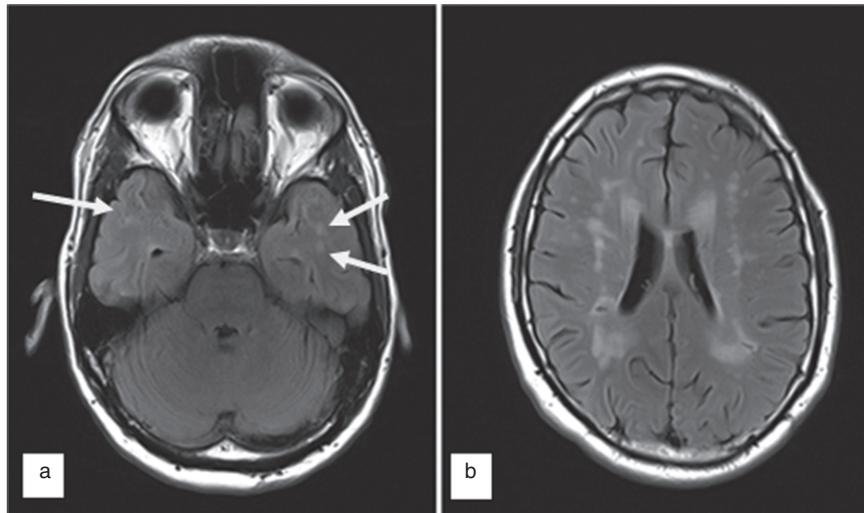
T2-fluid attenuated inversion recovery magnetic resonance imaging showing hyperintensities in cerebral autosomal dominant arteriopathy with sub-cortical infarcts and leukoencephalopathy. (a) Temporal lobe hyperintensities. (b) Diffuse white matter lesions.
